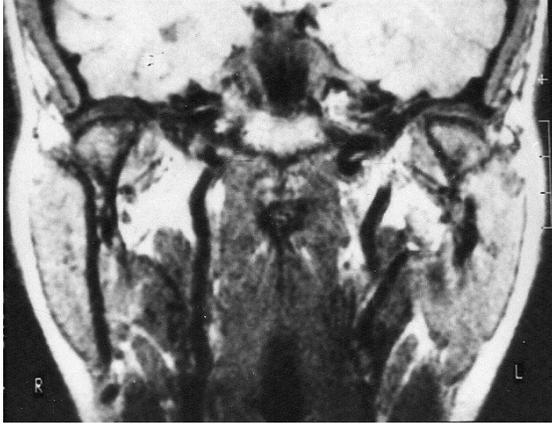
b: Coronal MRI reveals both condyles with no dislocation & minor damage.
